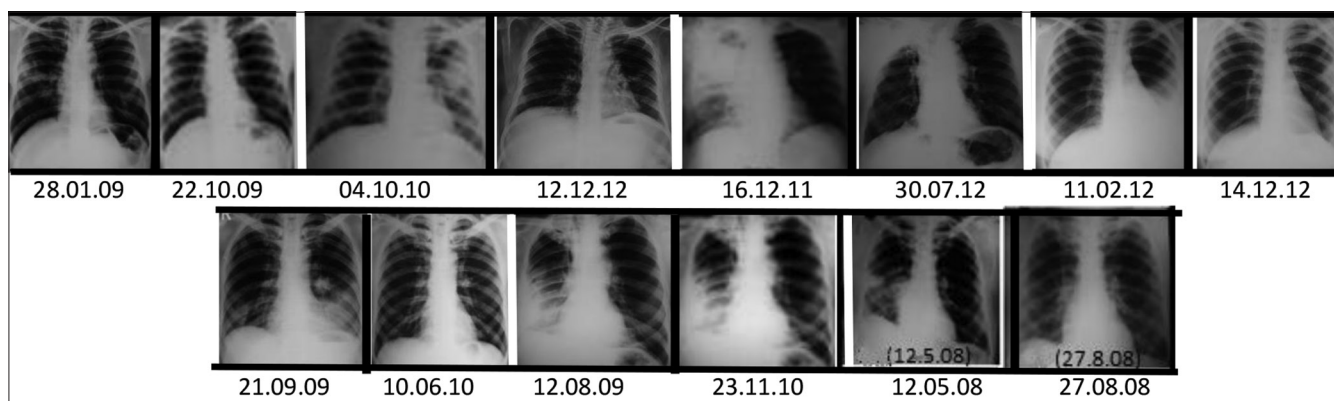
The picture elaborates the examples of changes in the different morphological lesions on long-term use of doxycycline. Each pair of photos of the x-rays (demarcated from the next by white bar) shows the change in each type of lesion that has been cured or reduced, except the case (second from the left at the lower panel) that did not show any change
